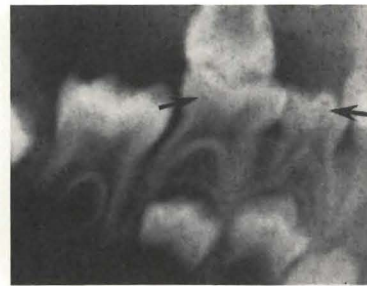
Magnified view of right side of panoramic radiograph. Note large stellate pulps and elongation of pulp horns into cusp tips (arrows).
